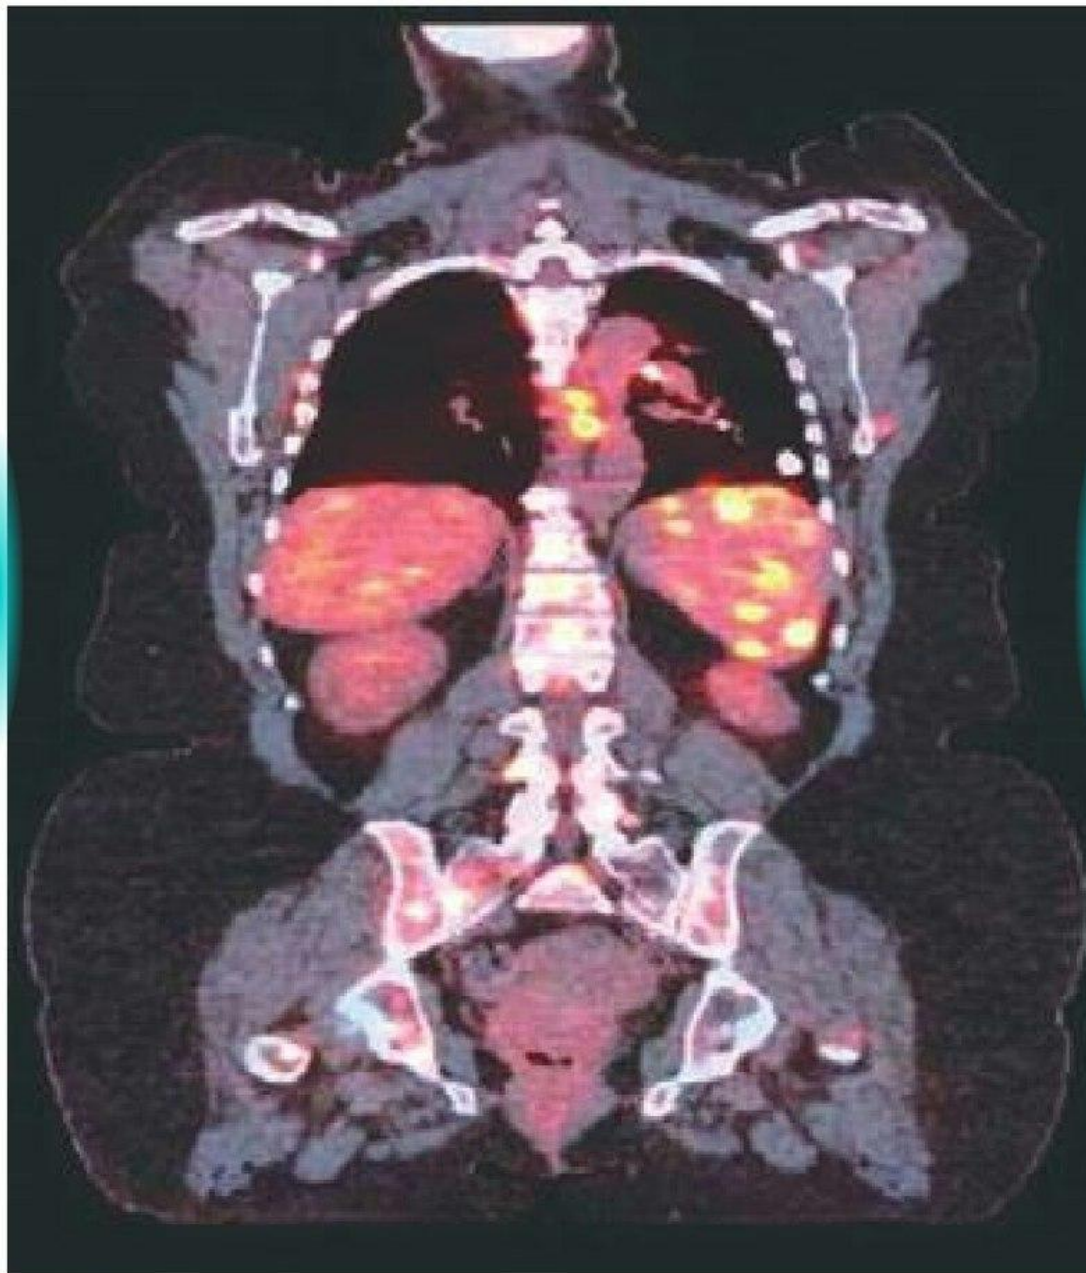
Positron emission tomography and computed tomography scan merged demonstrating increased activity in spleen, ribs, and spine of patient with sarcoidosis.
